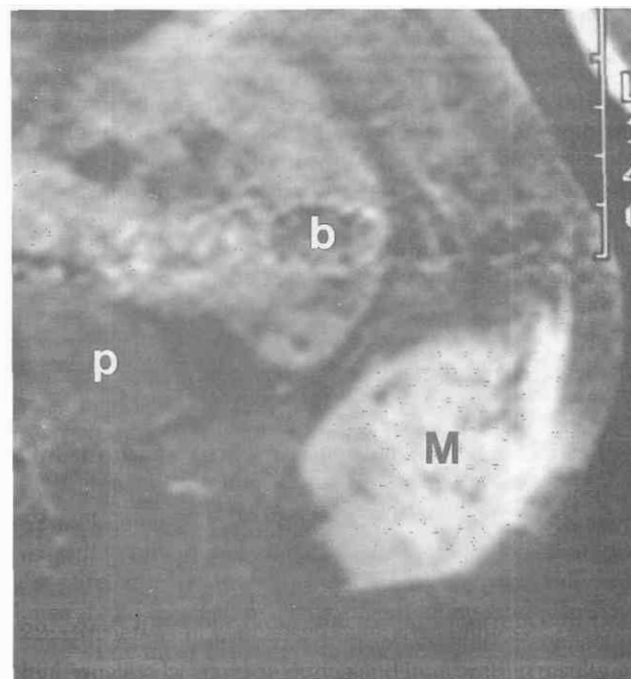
Aggressive fibromatosis of the posterolateral abdominal wall musculature in a 12-year-old boy. Axial postgadolinium T1-weighted image (TR = 700 msec, TE = 10 msec) with fat saturation shows marked enhancement of the mass (M). Lesion margins are irregular. b, bowel; p, psoas muscle.
